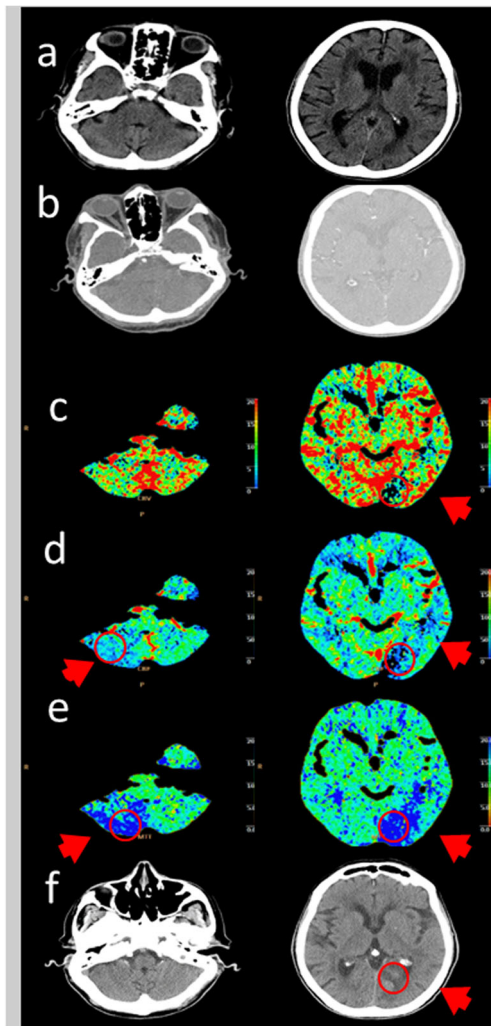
a Brain CT scan showing no abnormalities, pc-ASPECT 10. b CTASI showing no abnormalities, pc-ASPECT 10. c CTP with evaluation of CBV maps showing hypoperfused areas, pc-ASPECT 9 (left occipital area). d CTP with evaluation of CBF maps showing hypoperfused areas, pc-ASPECT 8 (right cerebellar and left occipital areas). e CTP with evaluation of MTT maps showing hypoperfused areas, pc-ASPECT 8 (right cerebellar and left occipital areas). f 24-h brain CT scan showing ischemic lesions limited at only one area in patients treated with reperfusion therapy (left occipital area)
